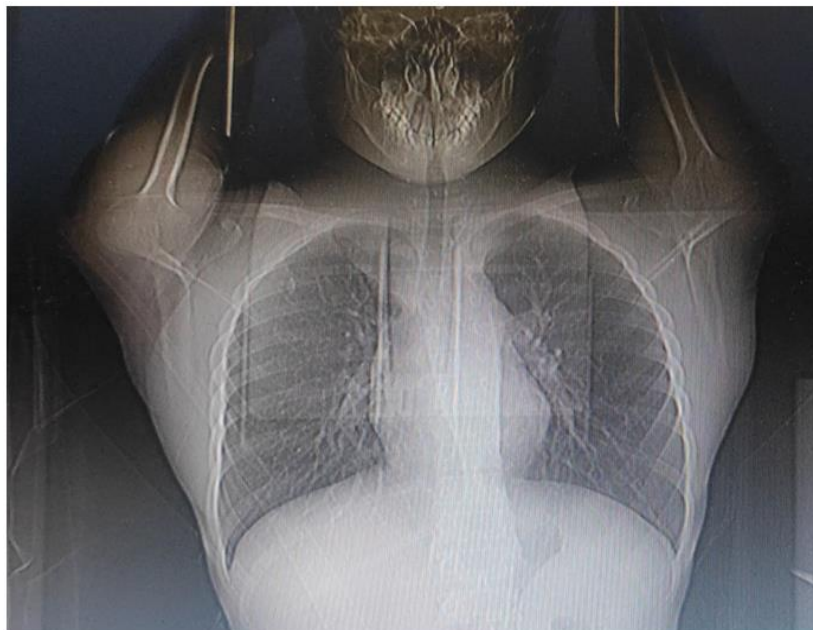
CT Neck and Chest which Reveals Bilateral IJV Thrombosis with Reactive Lymphadenopathy.
